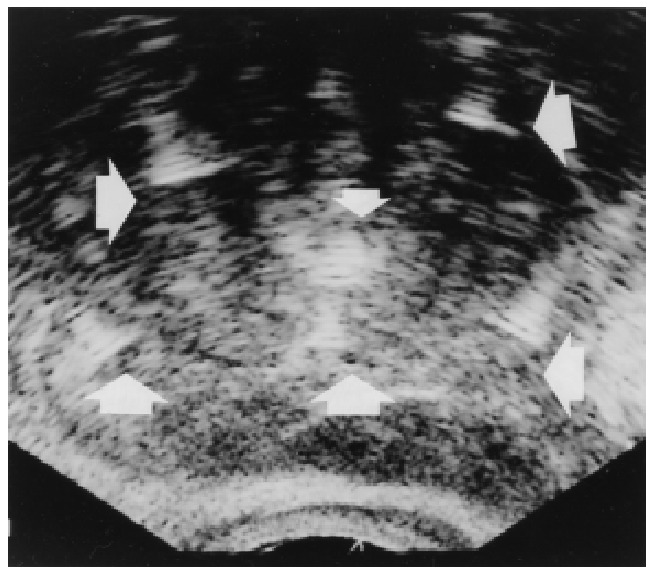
Transverse display of transrectal ultrasonography during placement of guidewires into the prostate. Five wires are seen peripherally (large arrows) plus an additional guidewire in a urethral catheter centrally (small arrow).
